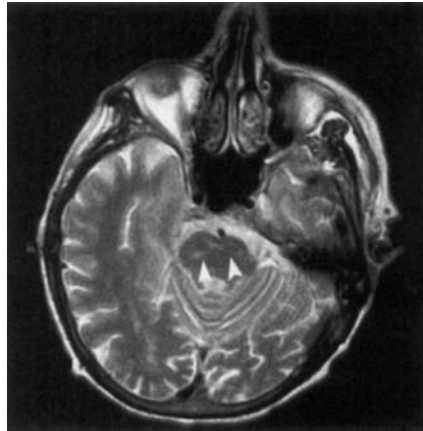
Cerebral magnetic resonance imaging: irregular lesions of the pontine region with hyperintense signal in T2-weighted images and hypointense signal in T1-weighted image (see white arrows)
